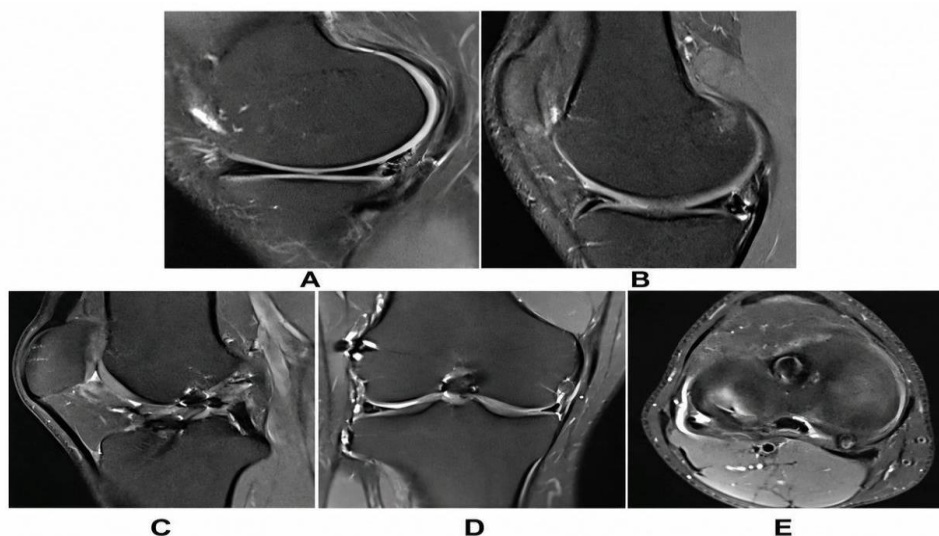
Preoperative magnetic resonance imaging (MRI) of the affected knee. A-C) Sagittal images demonstrating the status of the previous ACL graft; D) Coronal image; E) axial image demonstrating associated intra-articular findings
